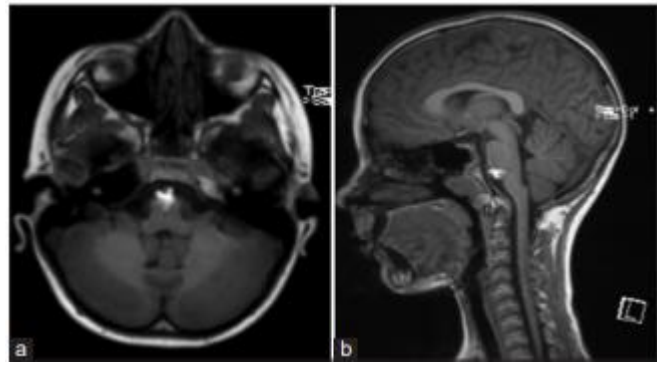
Magnetic resonance imaging of the brain during diagnosis. A spontaneously hyperintense mass can be seen anterior to the pontomedullary junction on (a) axial T1 and (b) sagittal T1.
